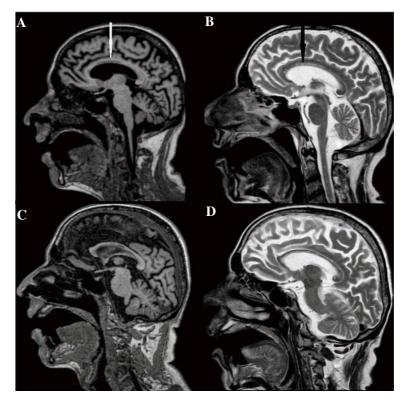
Brain MRI of a 45-year old man with Marchiafava-Bignami disease before and after treatment. A: Pre-treatment sagittal T1 weighted MRI reveals areas of necrosis in the body of the corpus callosum (white arrow). B: Pre-treatment Sagittal T2 weighted MRI reveals hyperintense signal involving the corpus callosum (black arrow). C and D: Post-treatment Sagittal T1 and T2 weighted MRI reveals no radiological improvement.
